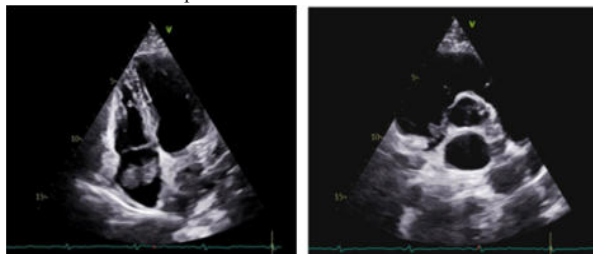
Transthoracic images depicting multiple hyper-echoic mass in the right atrium
